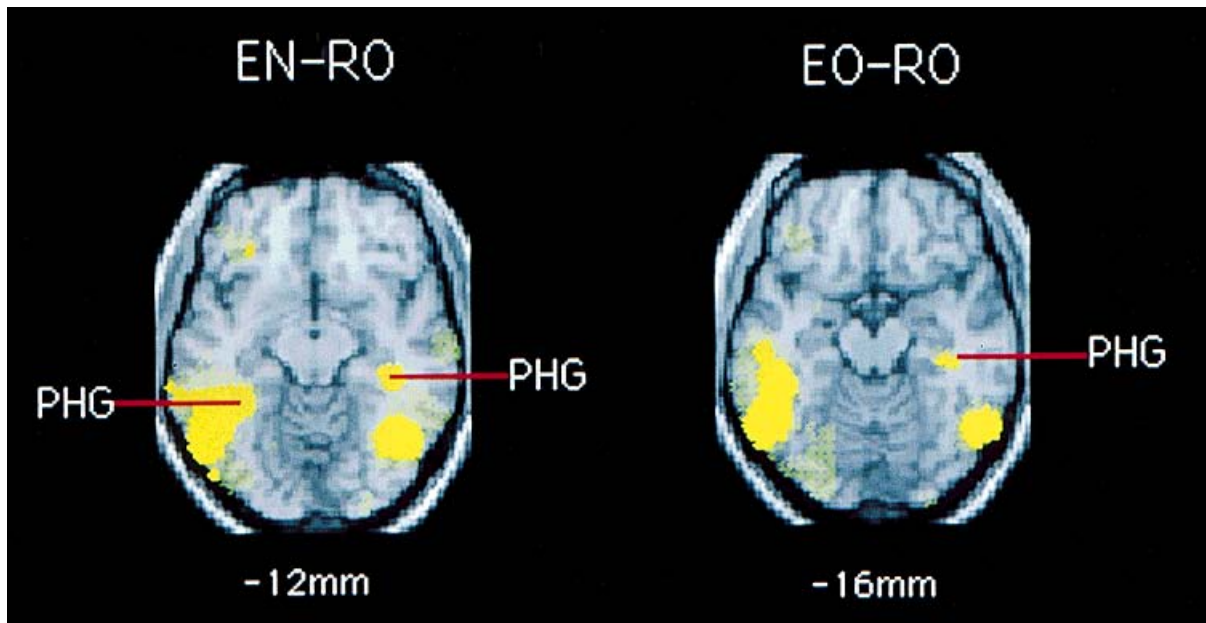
Significant increases in parahippocampal blood flow in two “Encoding minus Retrieval” subtractions. In each case, a statistical map of significant increases in regional cerebral blood flow ($P < .005$, uncorrected for multiple comparisons, in yellow) was superimposed onto a spatially standardized magnetic resonance image of the brain; the left side of each image corresponds to the left side of the brain. As indicated in a horizontal section 12 mm inferior to a plane through the anterior and posterior commissures, encoding new minus retrieval old (EN-RO) was associated with significantly
